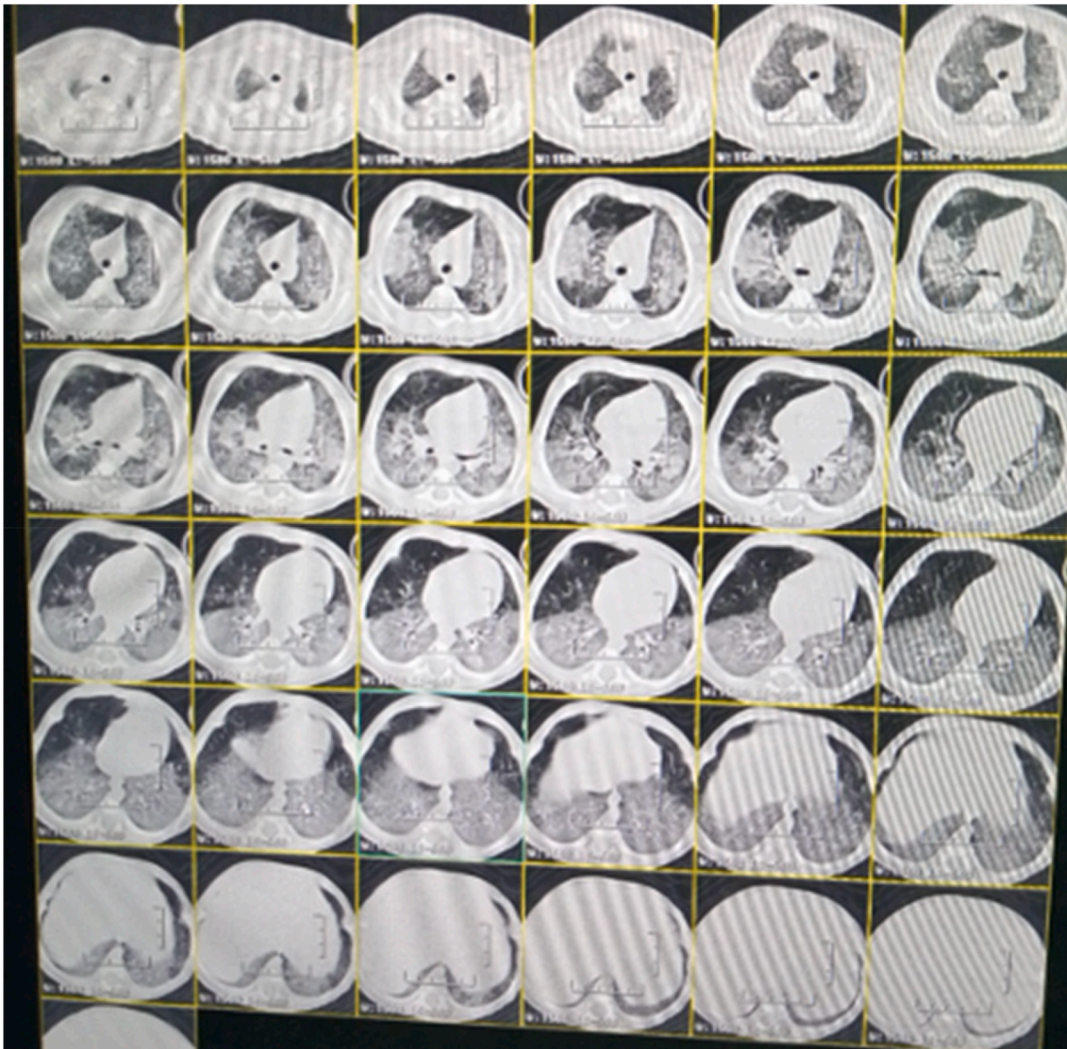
Transverse sections in parenchymal window of pulmonary CT showing SARS-CoV₂ (CORADS-5) pneumonia with frosted glass images and crazy paving.
